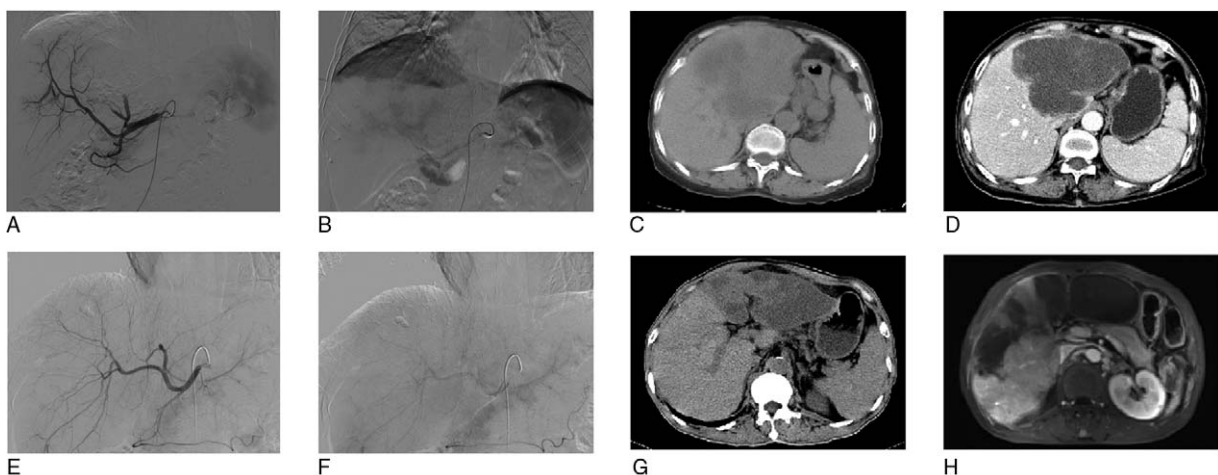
CT and DSA images of 2 patients at pre-operation and post-operation. (A–D) CT and DSA images of 1 patient at preoperation and postoperation. (E–H) CT and DSA images of another patient at preoperation and postoperation. Scan parameters were that: tube voltage was 120 kv; automatic pipe technology to adjust current; collimator width was 128 × 0.625mm; the reconstruction was 5mm; a thick layer of reconstruction interval was 5mm; screw pitch was 0.914. Enhanced scan USED MEDRAD double cylinder of high-pressure syringe injected iodine alcohol (containing iodine 300mg/ml) from peripheral vein intravenous (dose of 1.5 ml/kg). When abdominal aorta CT value arrive to 100 HU, it delays after 5 seconds and begins to scan, and after arterial phase late 30 seconds and 150 seconds, respectively, it began to scan portal venous phase and delayed phase.
